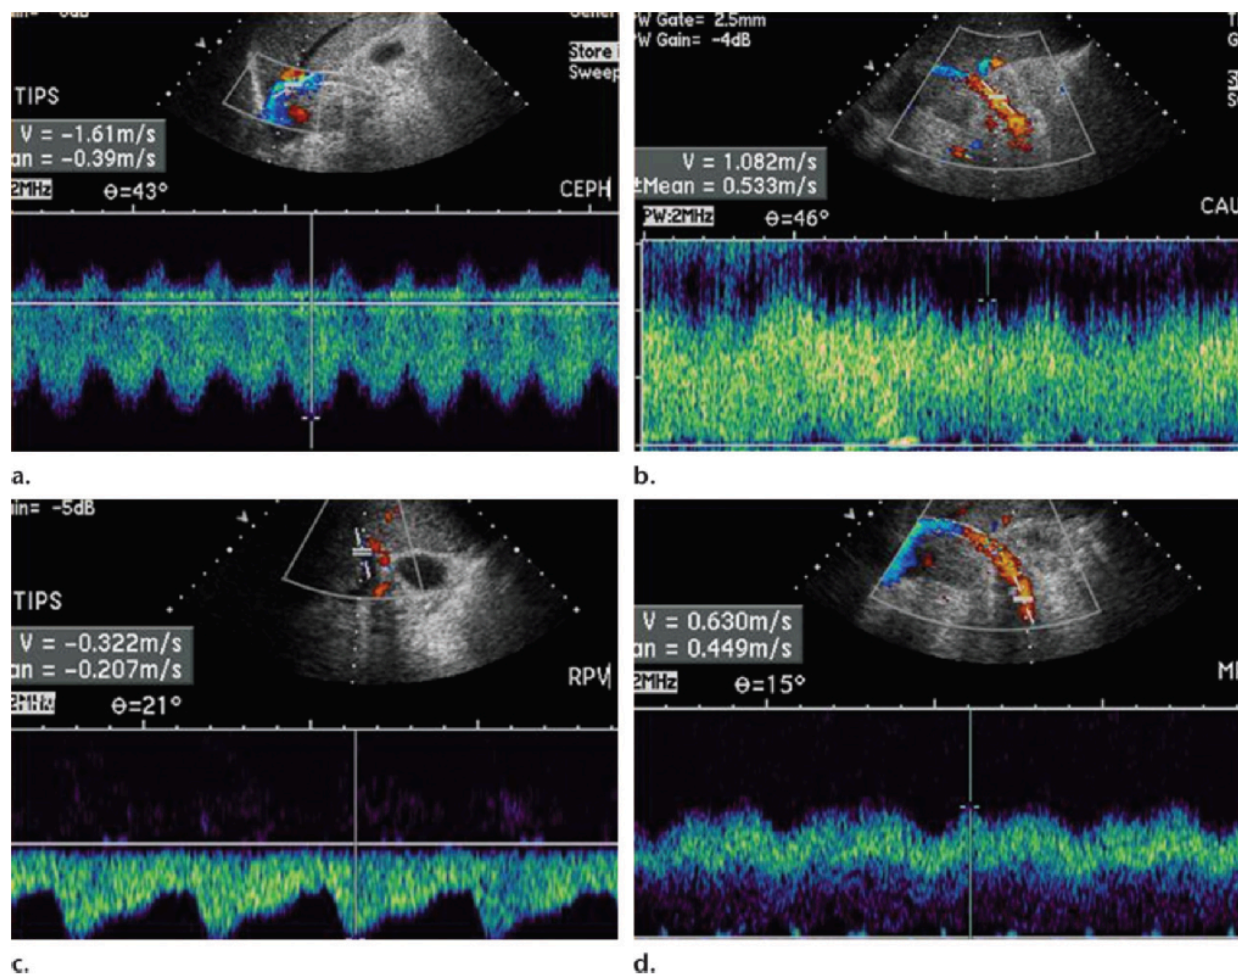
Normally functioning TIPS. (a) On a spectral Doppler US image, the color Doppler image shows the cephalic end of a TIPS in blue. The waveform is below the baseline, a finding that corresponds to antegrade flow. (b) Spectral Doppler image shows the caudal end of the TIPS in red. The waveform is above the baseline (antegrade flow). (c) On a spectral Doppler US image of the right portal vein, the waveform is below the baseline. Flow within the vein is hepatofugal, as would be expected in a functioning TIPS. Left portal venous flow was also hepatofugal. (d) Spectral Doppler US image shows the main portal vein in red and a waveform above the baseline, both of which findings indicate the expected hepatopetal flow. The velocity ($>16\text{ cm/sec}$) is not low, a finding that supports the patency of the TIPS.
